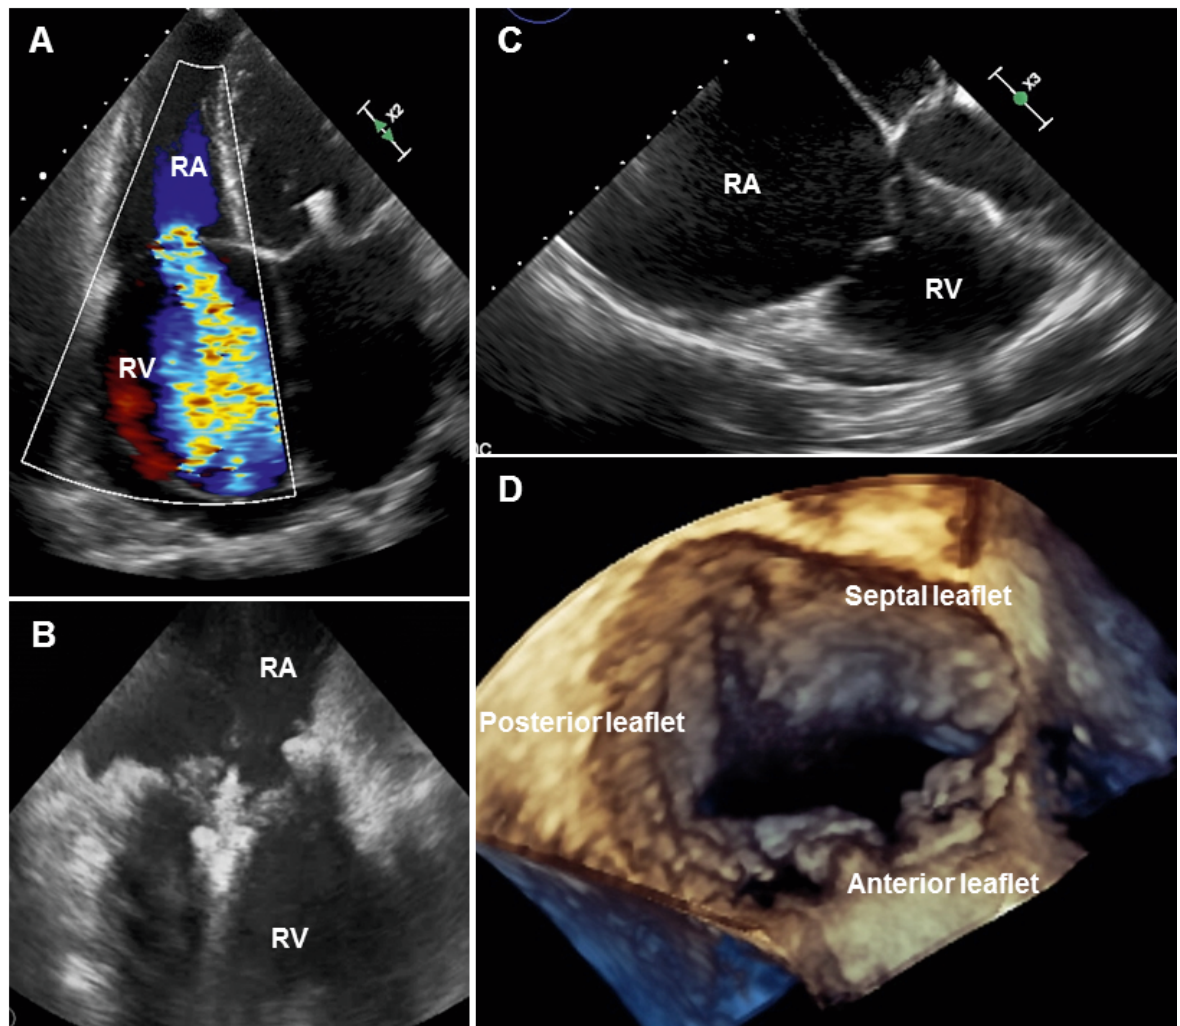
Echocardiographic image of tricuspid valve.
